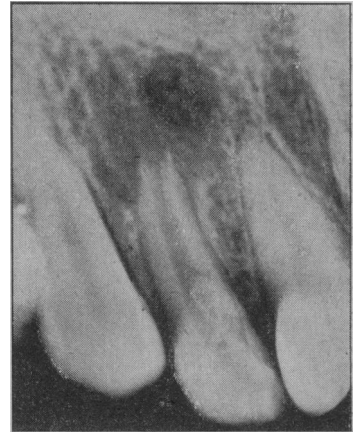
(*Case I*).—Intra-oral radiograph showing the periapical condition of the invaginated right lateral incisor.
